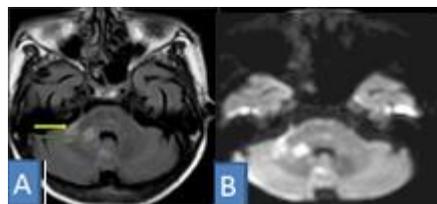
A case of Progressive Multifocal Leucoencephalopathy in an immunocompromised patient showing hyperintense lesions in right brachium Pontius extending to right cerebral hemisphere on FLAIR (A), showing restriction on DWI (B).
